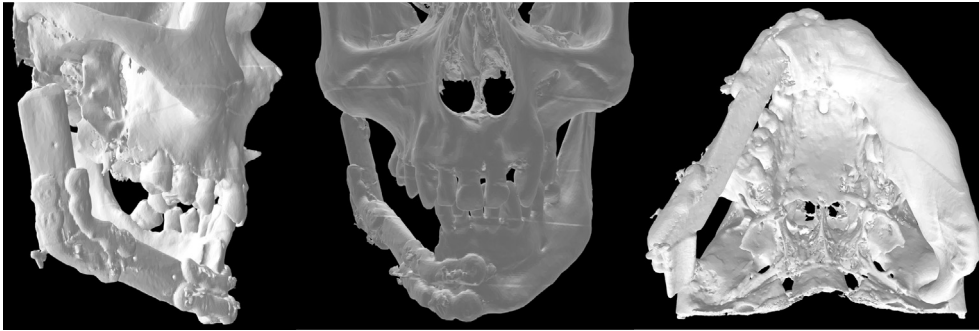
Three-dimensional reconstruction of post-operative CT scan images.
